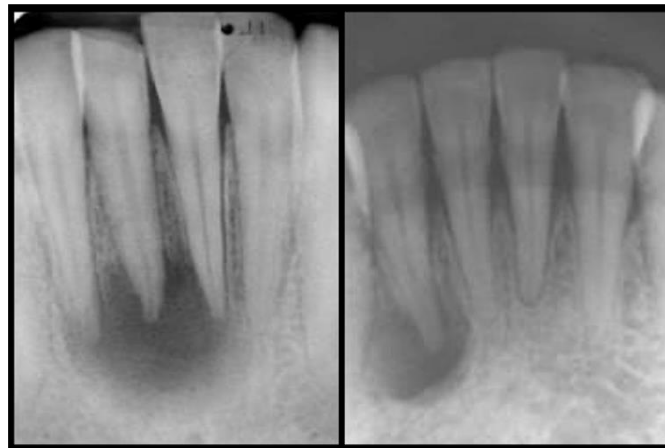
Mandibular teeth associated with a large periapical lesion¹⁵
